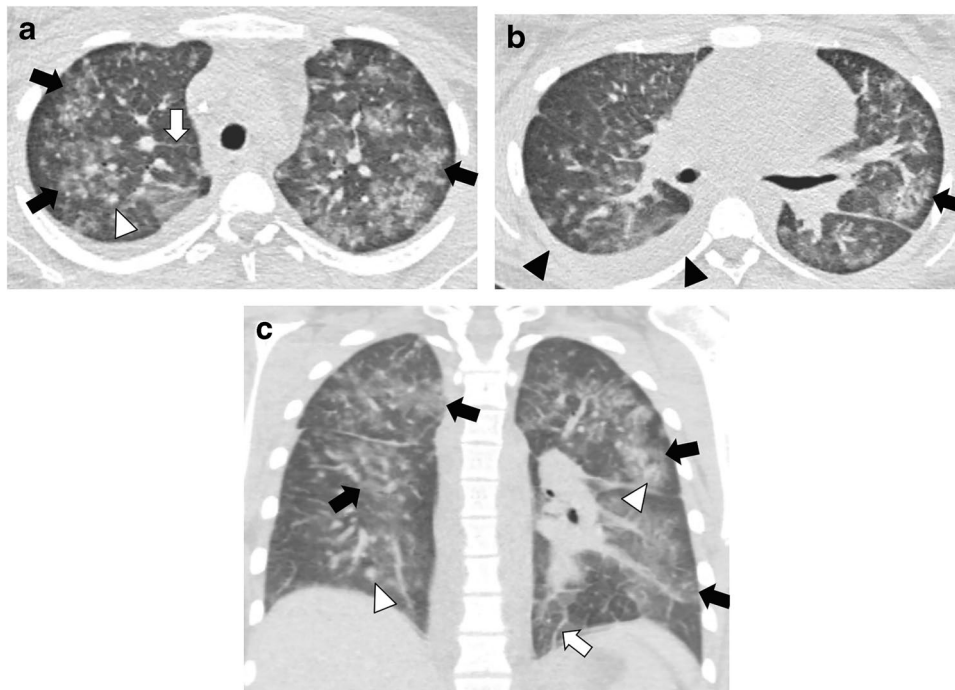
Unclassified idiopathic pulmonary syndrome (IPS) in a 16-year-old girl with history of acute lymphocytic leukemia (ALL) day 13 post allogeneic hematopoietic cell transplant (alloHCT). IPS was diagnosed clinically based on respiratory status and absence of findings of infection. The girl improved clinically and radiographically (*not shown*) after treatment with steroids and etanercept. a-c
